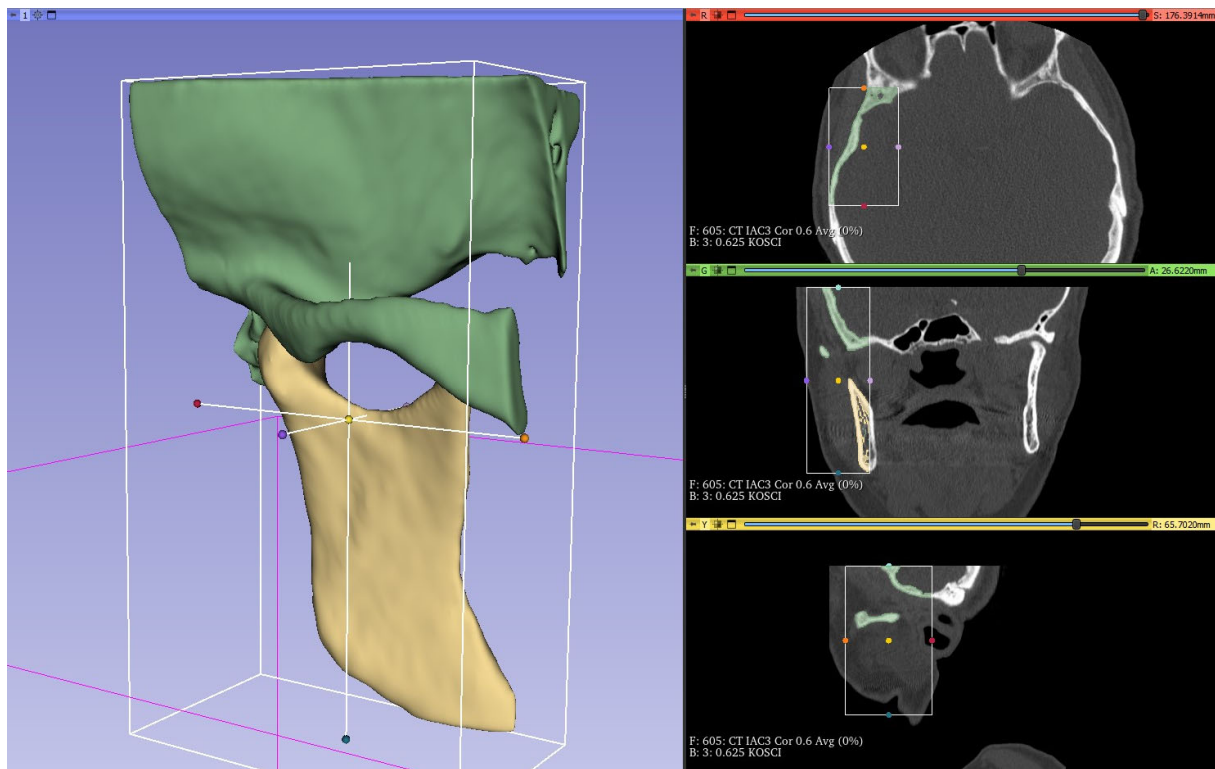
Segmentation of the temporomandibular joint based on patient CT images in Slicer software. The segmented object can be used for 3D printing.(Own study, 2022)
